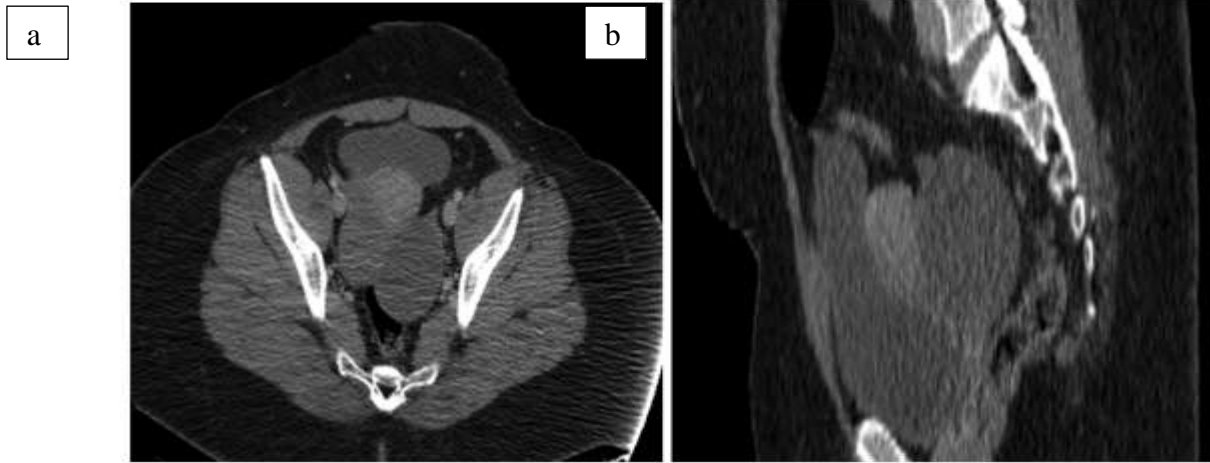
a-b : CT scan in axial section showing 2 bilateral lateral uterine cystic lesions
